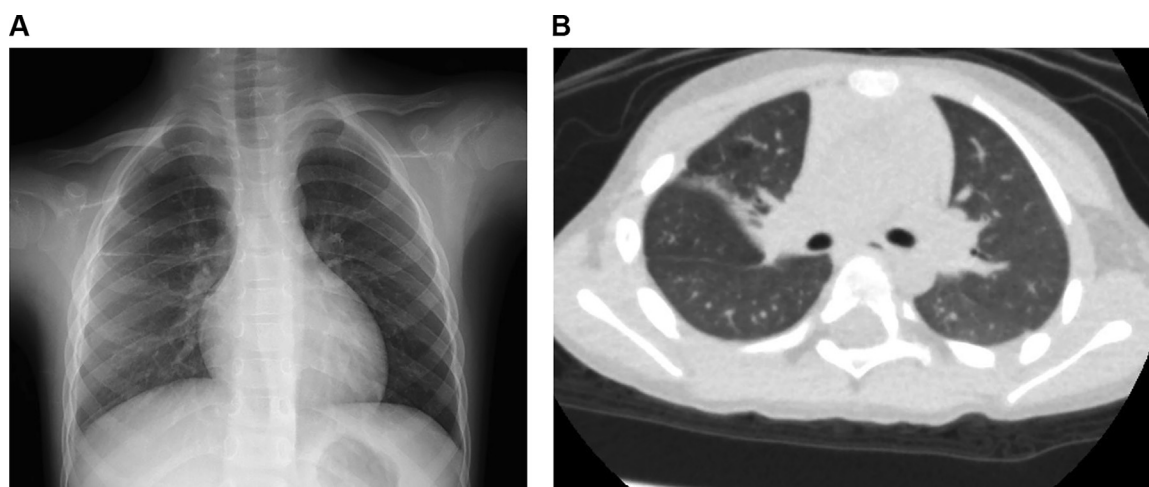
Chest X-ray showing an opacity in the right upper field and pleural effusion in the right thoracic cavity at Day 1 of hospitalization.
